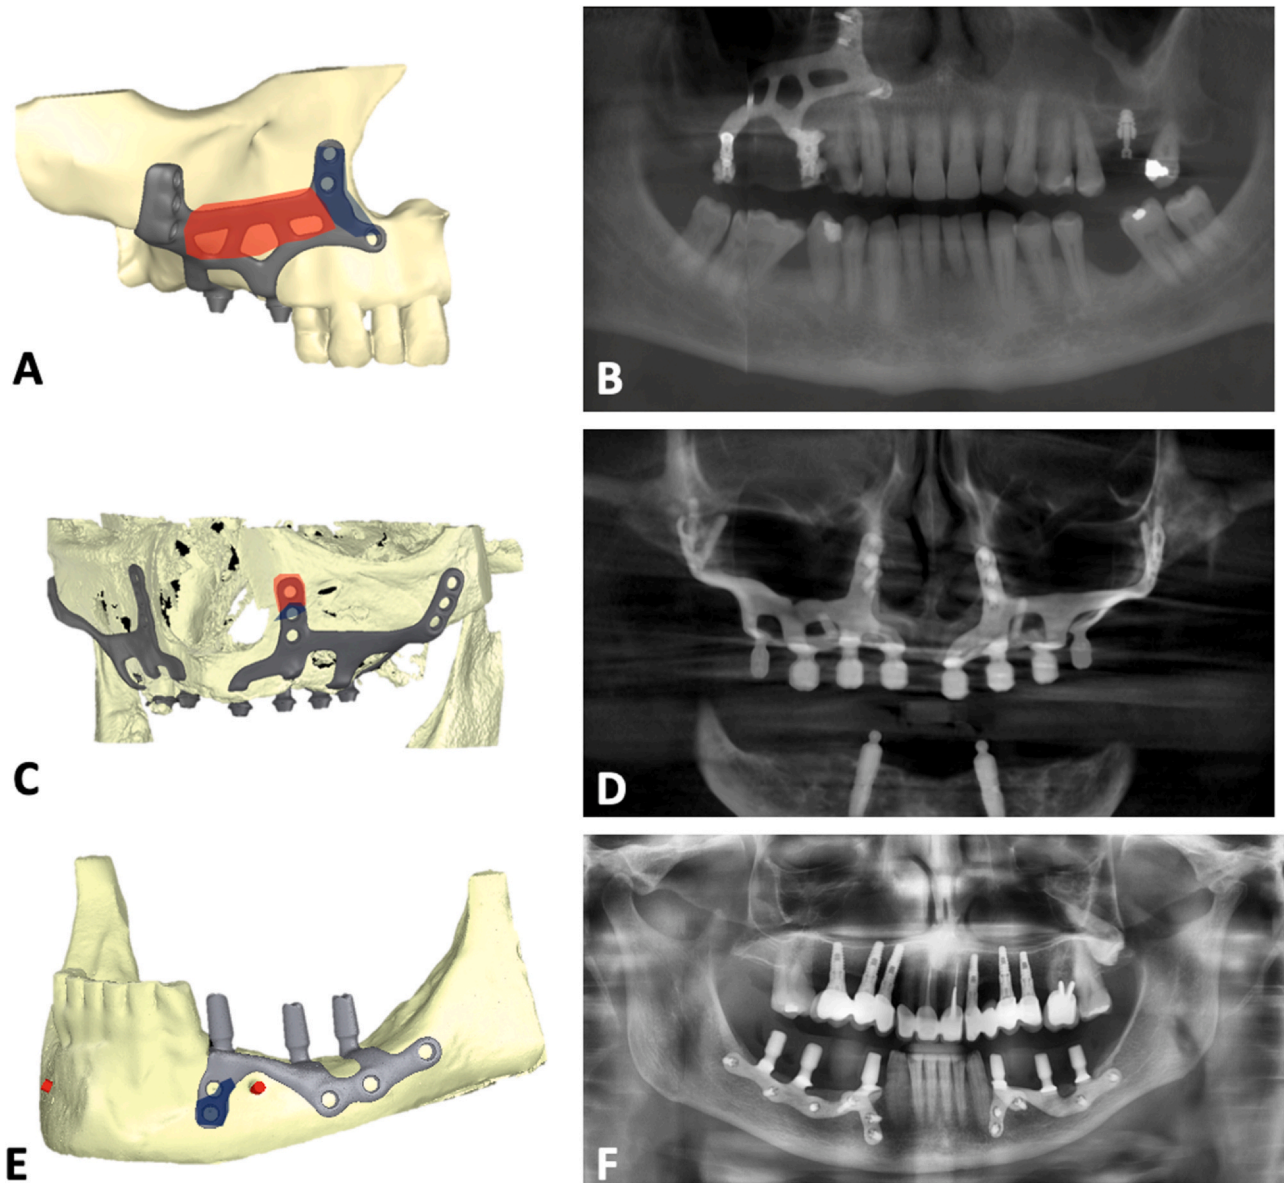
Digital implant design, areas of bone apposition, and corresponding panoramic imaging. (A, C, E) Graphical representations of the patient-specific subperiosteal implant frameworks. Areas of bone apposition observed during surgical re-entry are highlighted: red indicates regions of complete bone apposition, while blue indicates regions of partial bone apposition. (B, D, F) Corresponding panoramic radiographs showing the subperiosteal implants in situ.
